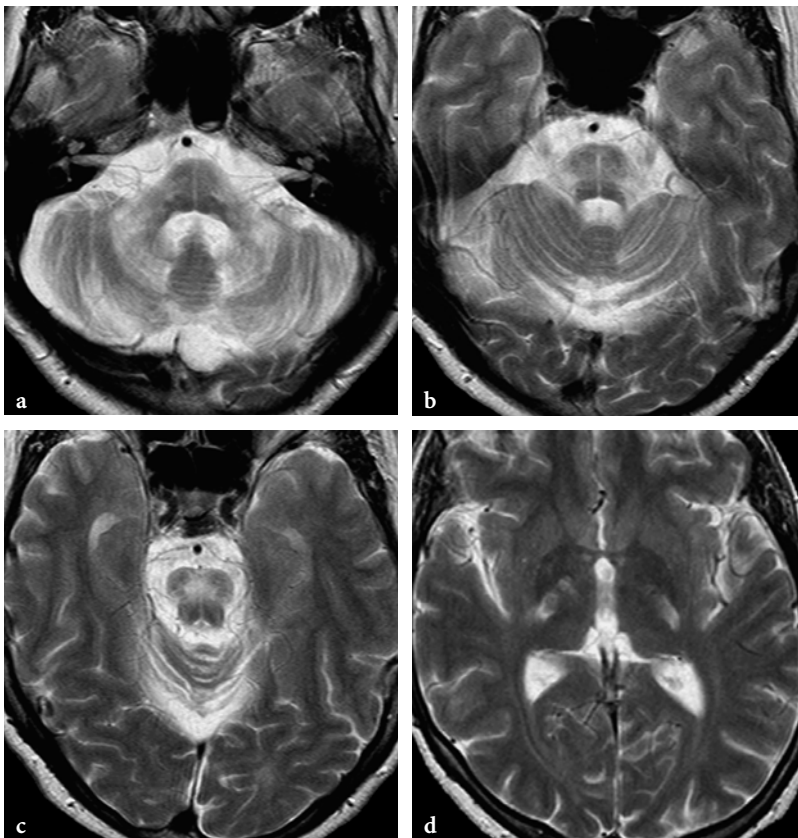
MR imaging findings in adrenomyeloneuropathy. a-d Axial T2-weighted fast spin-echo images. Atrophy of brainstem and cerebellum in conjunction with abnormal signal intensities involving the white matter (note relative sparing of tegmental structures at the level of brainstem) and extending to posterior limbs of internal capsules bilaterally
